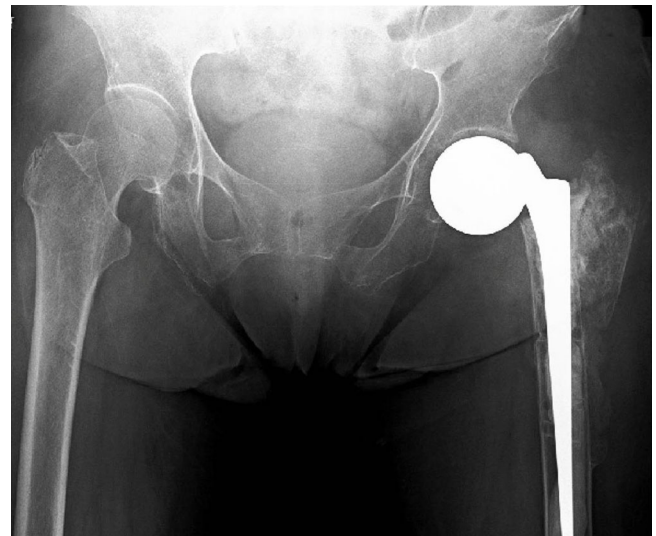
Six-week follow-up plain radiograph.
